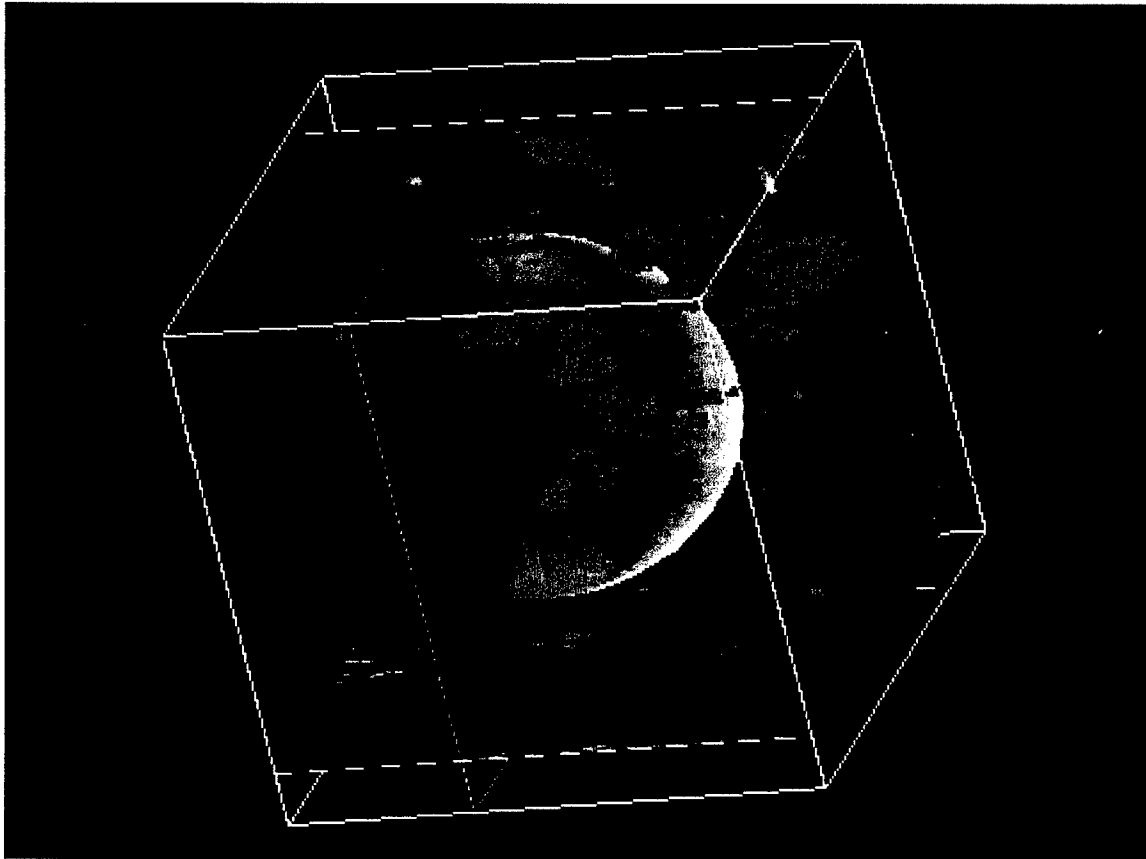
Example of a radiologist defined ellipsoid. Three ultrasound image planes are shown in the example, highlighted with 3D rendered vascularity in a 55 year old patient with invasive ductal carcinoma with lymphatic invasion. Two of the image planes are reconstructed from the 3D volume. The vascularity is apparent, mostly in the immediate periphery of the ellipsoid.
